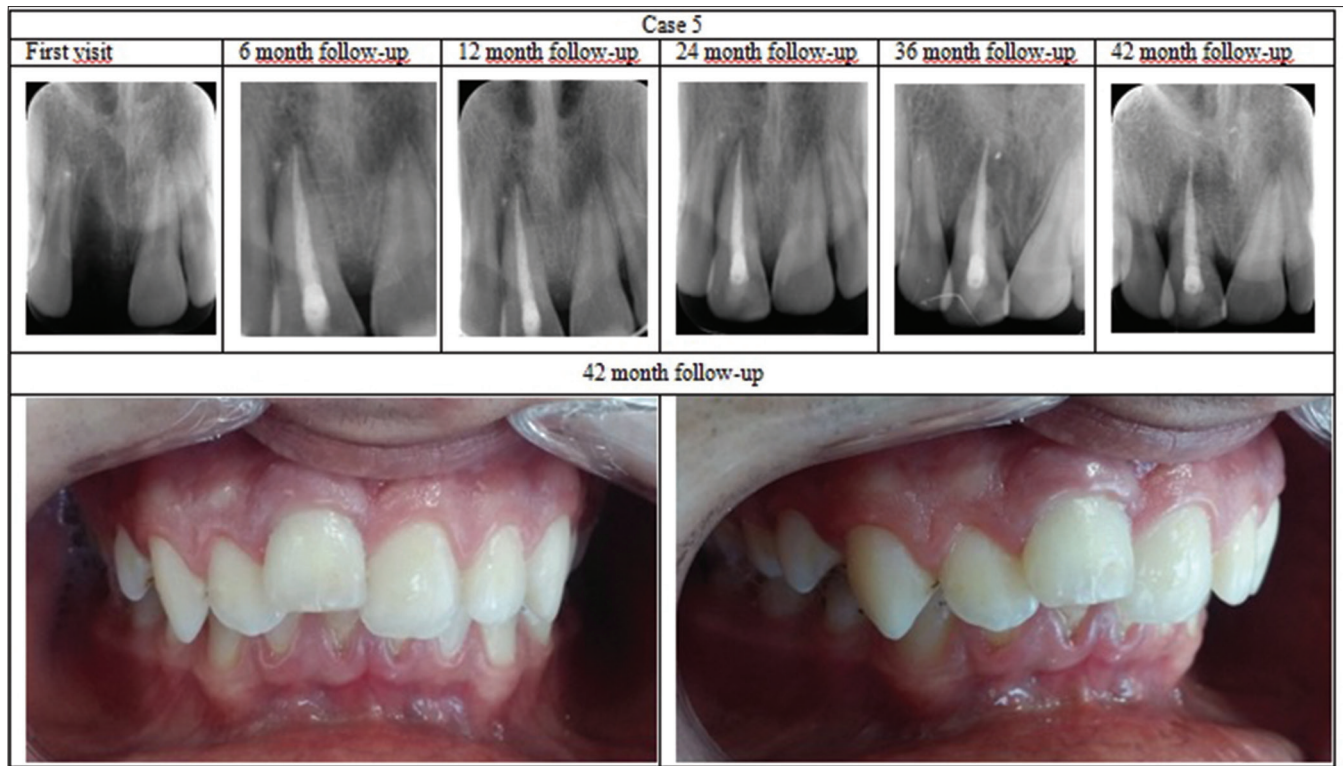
Radiographic and clinical records of case 5
